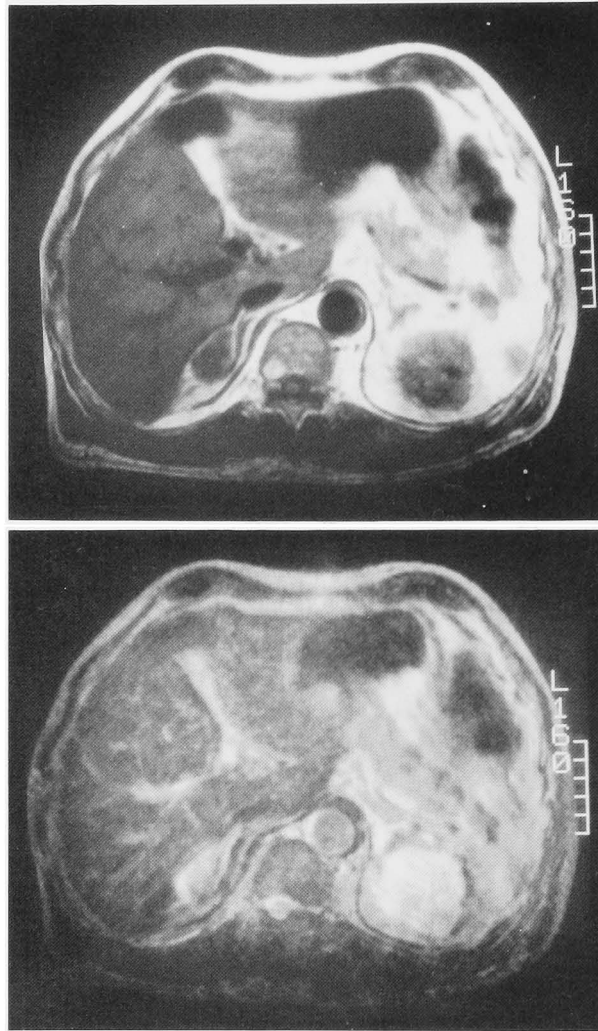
MR images. Upper. T1-weighted. The tumor showed low intensity. Lower. T2-weighted. The tumor was hyperintense.
